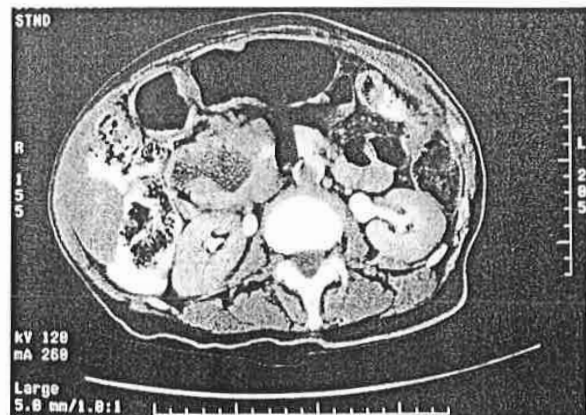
CT scan of abdomen demonstrating 6 × 3-cm mass on the head of the pancreas.
